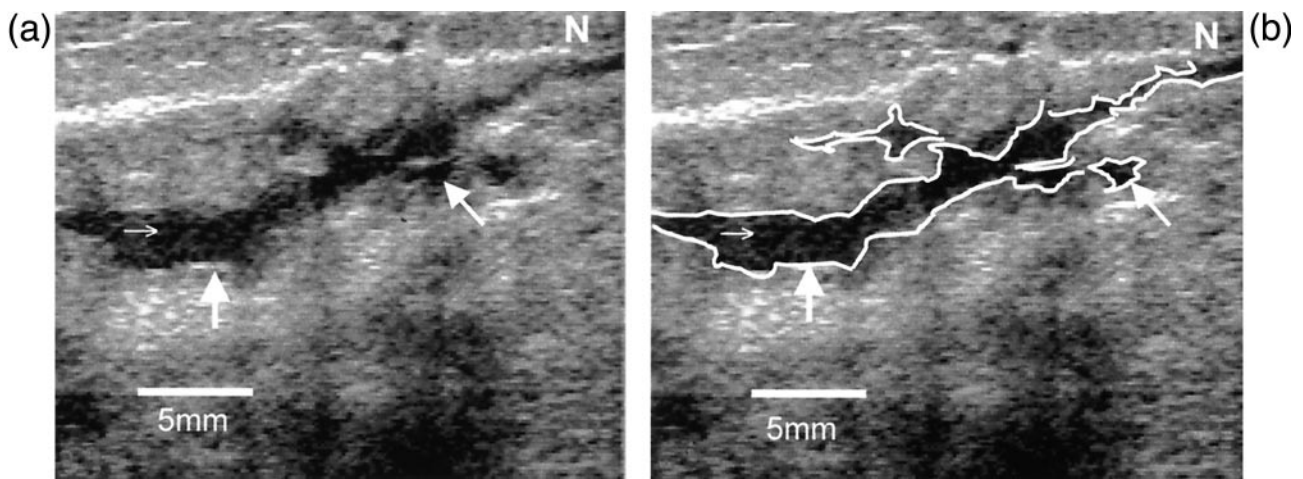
a, Ultrasound image of milk duct in the lactating breast. The duct is traced from deep in the breast to the nipple (N). The walls are echogenic (↑) and the lumen is hypochoic (→). Note the echogenic flecks within the duct that are consistent with fat globules in the breast milk. A small branch is noted (↖). b, The milk duct is outlined.
